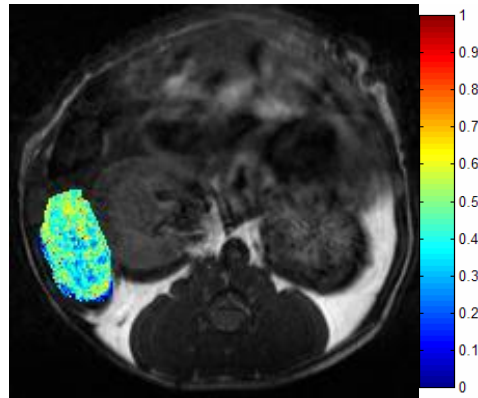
Calculated blood volume density (au) map overlaid on MRI image
